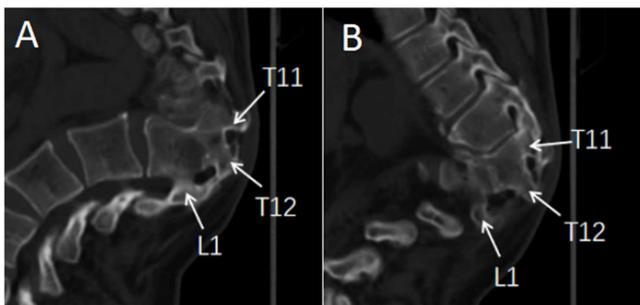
Preoperative CT scan of deformed vertebral pedicles: L1, T11, and T12 vertebral deformities and fusions can be seen on the sagittal plane of spine CT, but the pedicles are intact.
